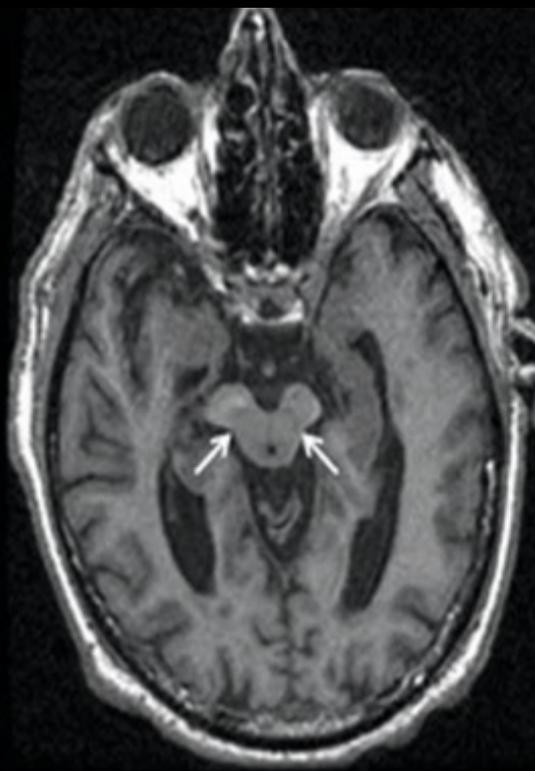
The "swallow tail" sign. All MRI presented above are taken at the level
